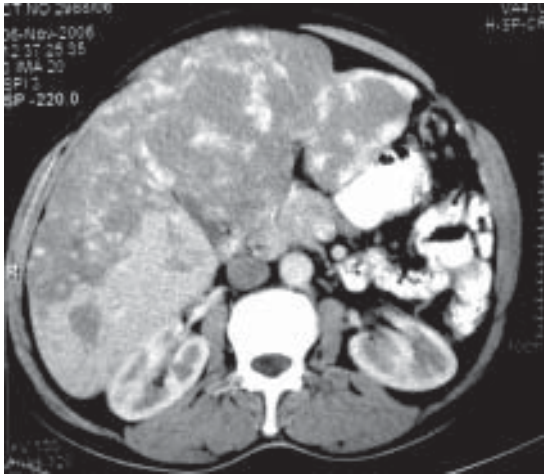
CT scan showing diffuse haemangiomas involving both lobes of liver.
